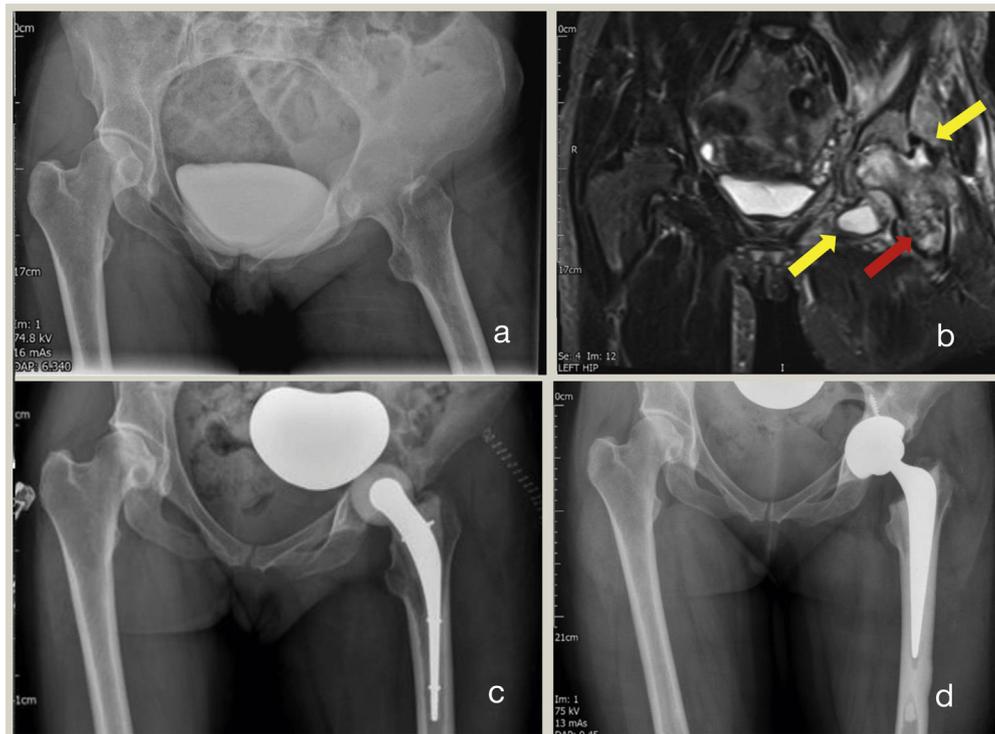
(a) X-rays of a 33-year-old female patient with septic arthritis of the left hip due to intravenous drug abuse. None of the six samples sent for microbiological analysis showed growth after 10 days. (b) The T2-sequences of the MRI shows effusion (yellow arrows) of the left hip joint and oedema (red arrow) of the femoral head and neck. A two-stage procedure for a primary total hip arthroplasty was performed. (c) An X-ray after the first stage (a polymethyl methacrylate (PMMA)– cement spacer was implanted) and (d) shows an X-ray of the pelvis after the second stage and reconstruction of the hip with a total hip prosthesis (the cup was fixed with a screw).
